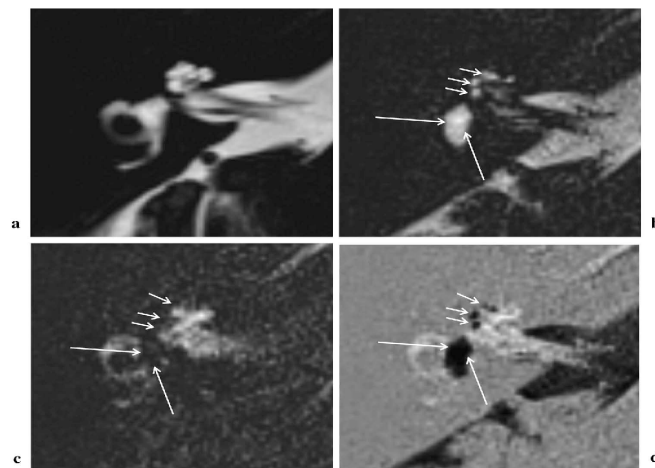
One sample of the MRI data of a patient diagnosed with bilateral Menière's disease. A: T2-weighted CISS sequence of the right side inner ear. B: positive endolymph image acquired by a T2-weighted 3D IR sequence. C: positive perilymph image obtained by T2-weighted three dimensional FLAIR sequence. D: HYDROPS image obtained by the subtraction of the positive endolymph from the positive perilymph images [132] [7] [75] [76].
